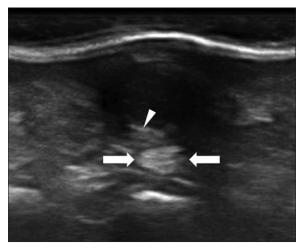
Ultrasound image showing a poorly circumscribed hypoechoic mass with posterior acoustic enhancement (arrows) and hyperechoic strips (arrowheads)
